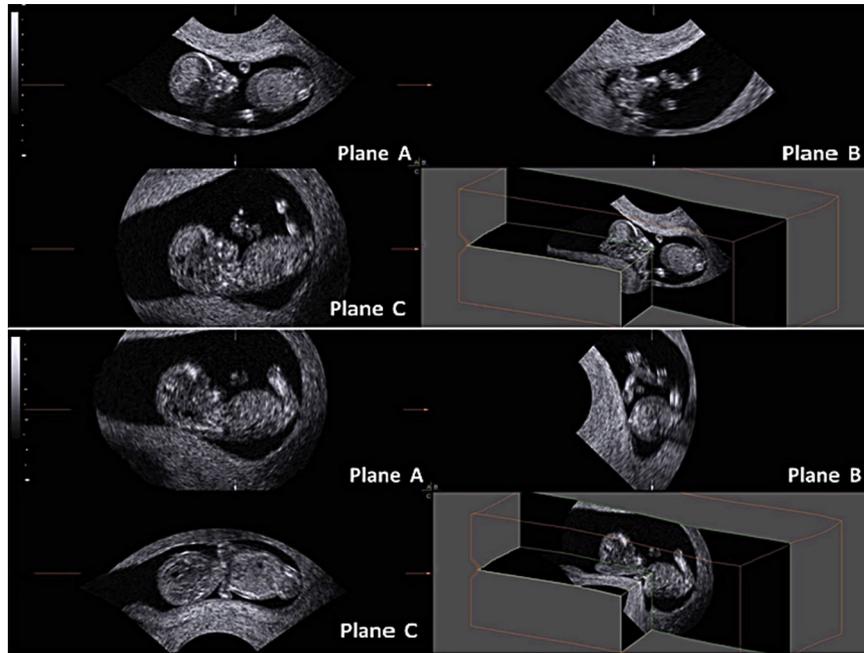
Three-dimensional ultrasound in multiplanar mode in a first-trimester fetus. The acquired image acquired is at the top. After rotating and moving the 3-D data set, one can place the fetus in a standardized manner, with the sagittal plane in the A image, the transverse plane in the B image and the coronal plane in the C image. With the standardized image, it is possible to discern that the fetus is bending to its right, which can interfere with measurement of crown-rump length.
